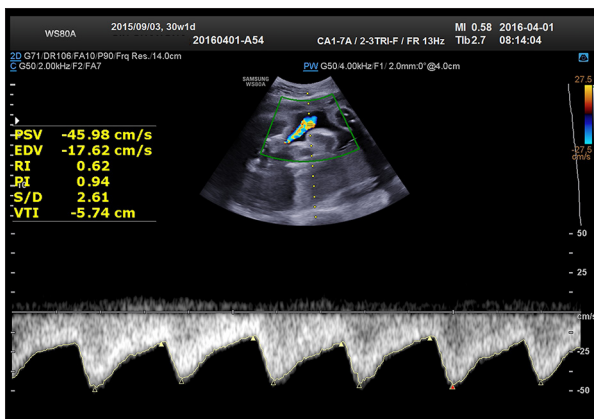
Ultrasound Doppler spectrum of fetal UA in the placenta previa group.
